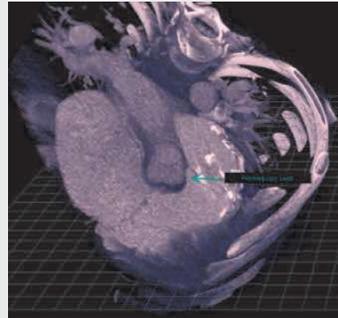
CT on True3D Viewer (EchoPixel, Inc., Mountain View, CA) showing paravalvular tunnel measuring 8x6x9 mm in the posteromedial side of the pulmonary valve
